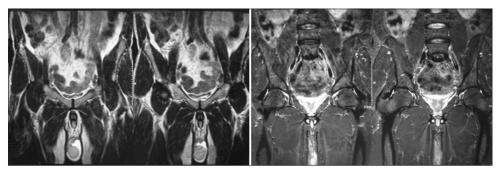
MRI pelvis showing thickened cortex with altered signal intensity involving left iliac bone
